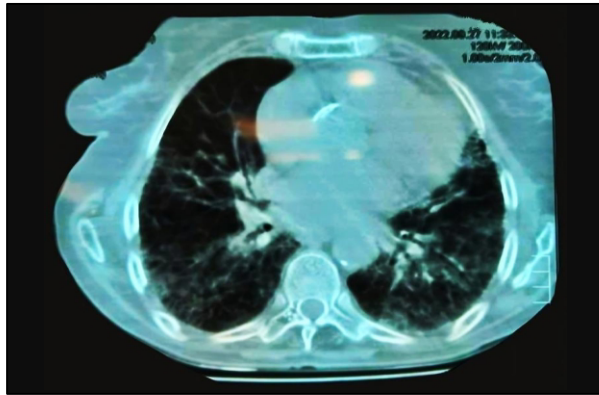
High-resolution computed tomographic scan showing classical bilateral ground glass opacities
